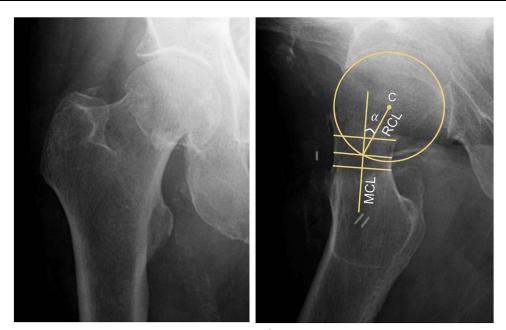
Posterior tilt measurement using the methodology described by Palm et al¹ on lateral hip radiographs. A lateral hip radiograph is used for measuring the posterior tilt with this methodology. As described in the article, the posterior tilt is the angle (α) measured between the mid-collum line (MCL) and the radius collum line (RCL). Three perpendicular lines are drawn across the collum with the middle one at the narrowest part of the neck. The MCL is drawn perpendicular to these 3 lines. The RCL runs from the center (c) of the femoral head caput circle to the crossing of the MCL and the caput circle.
